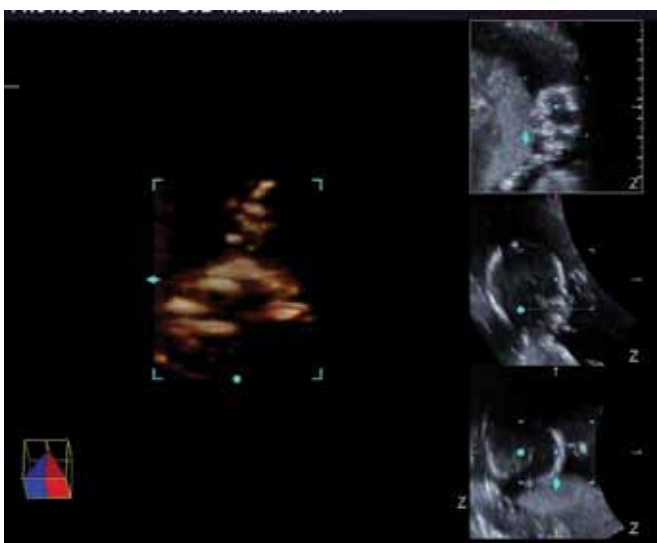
A 16-week fetus. Multiplanary ultrasonography, with A quadrants, from the right part, middle, with the extremity sagittal section of fetal skull, B quadrants, top right part with the coronal section, C bottom right part with axial section. In the left part – the volume with “bottom view” of the jaw and primary palate with a Skeletal Rendering soft, the quadrangle dotted with green representing the volume in the three quadrants A, B, C
